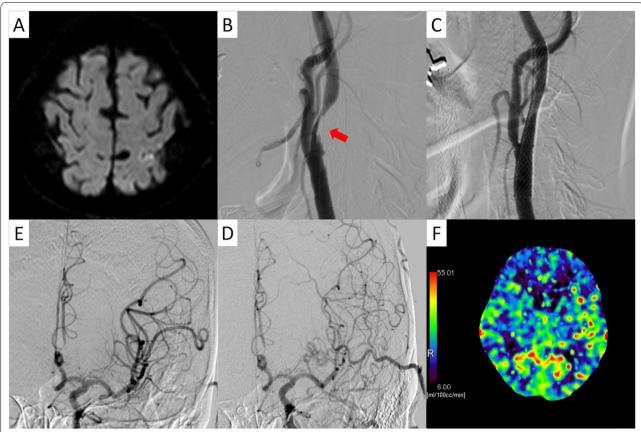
A Diffusion-weighted imaging performed upon admission revealed multiple cortical cerebral infarctions. B, C Carotid artery stenting was performed for internal carotid artery stenosis (red arrows). D Preoperatively, atherosclerotic stenosis was observed in the left anterior cerebral artery. Digital subtraction angiography (DSA) was performed at the end of the surgery, and the results showed that the left middle cerebral artery (MCA) was dilated. E DSA performed 1 day after the surgery revealed a localized vasoconstriction mainly of the left MCA. F One week after the surgery, CT perfusion revealed hyperperfusion, with a cerebral blood flow contralateral ratio of greater than 1.3. CT perfusion was scanned using a multidetector CT scanner with 80 detector rows (Aquilion Prime, Canon, Japan) and DSA was performed with biplane equipment (Infinix Celeve-i INFX-8000 V, Canon, Japan). MRI scanner was 1.5 T scanner (Magnetom Avanto fit, Siemens Healthcare, Germany)
